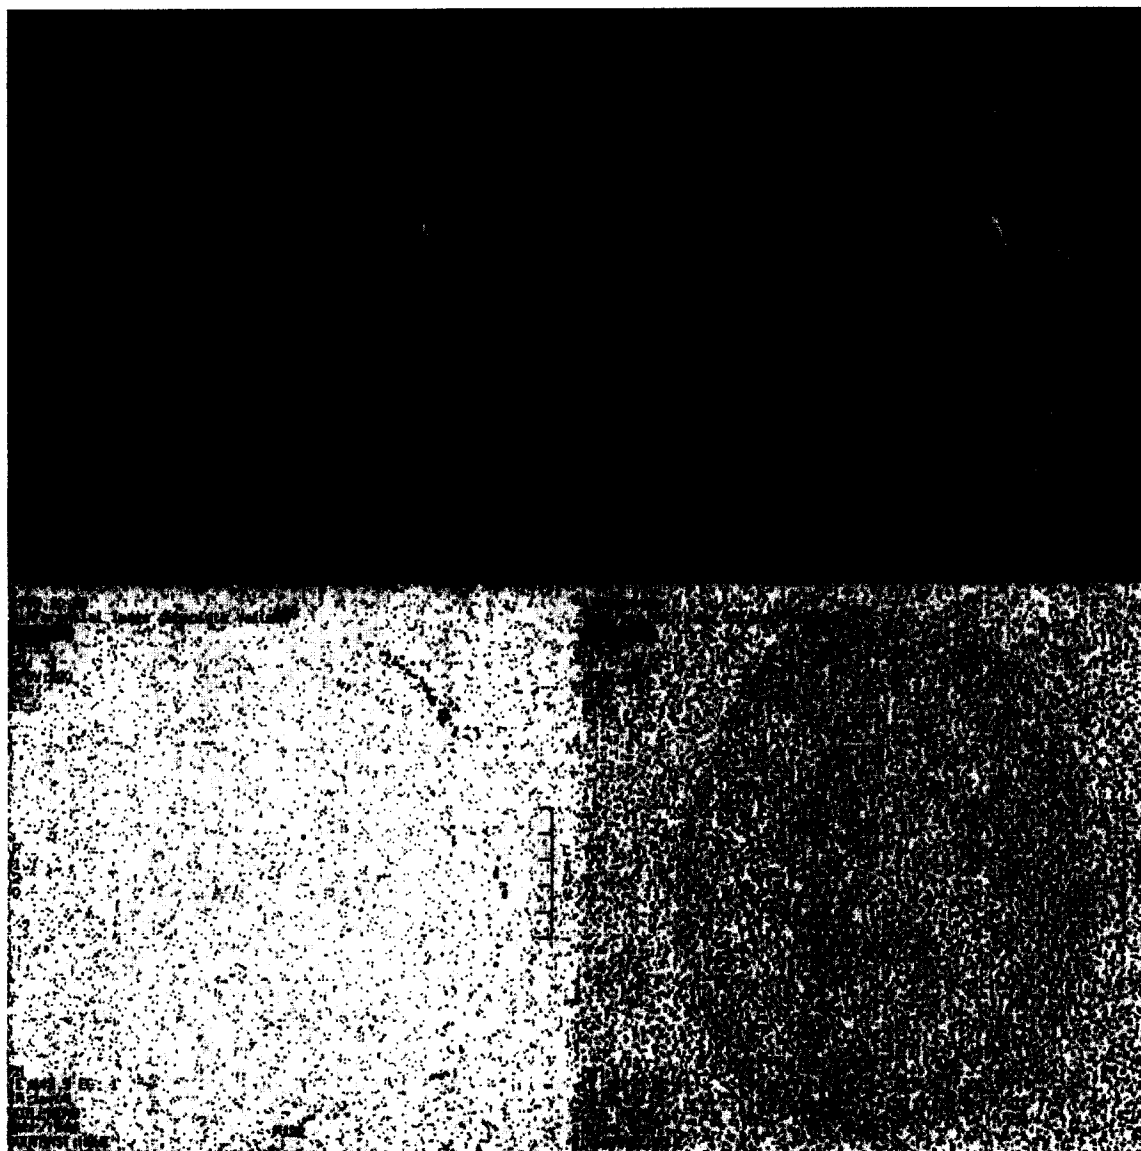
Original MR image (top, left), MR image wavelet compressed 5:1 (top, right), absolute difference image (bottom, left), and signed difference image (bottom, right).
